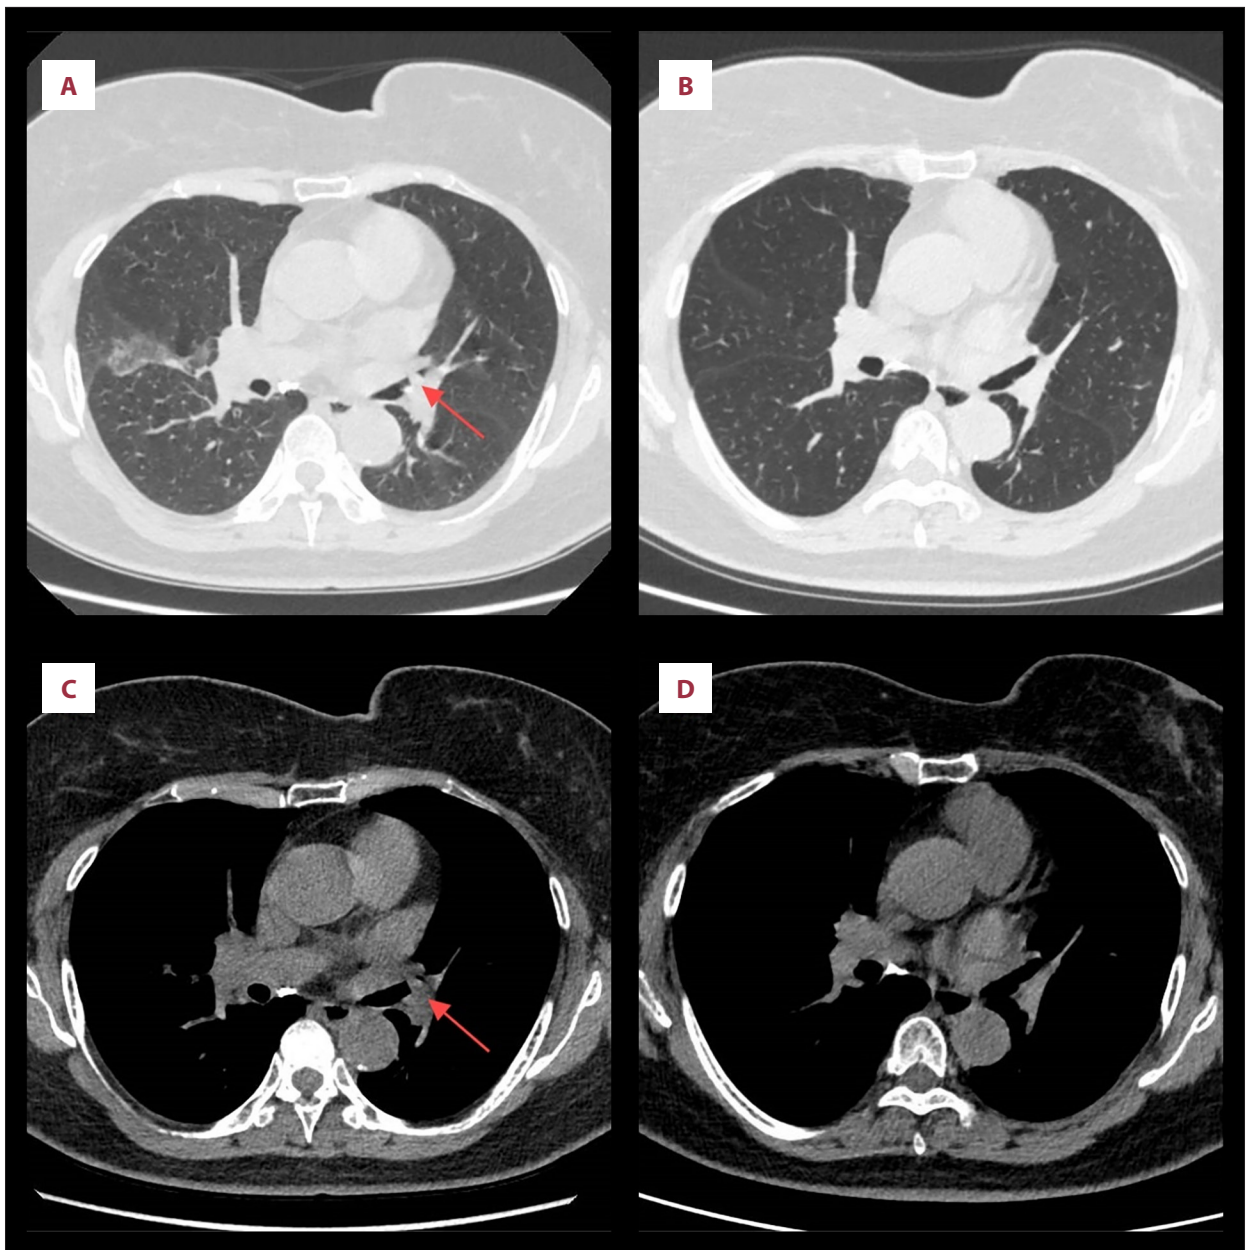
(A, C) Thoracic CT showing the leiomyoma in the left upper lobe bronchus. (B, D) Follow-up chest CT 6 months after successful resection. CT, computed tomography.
